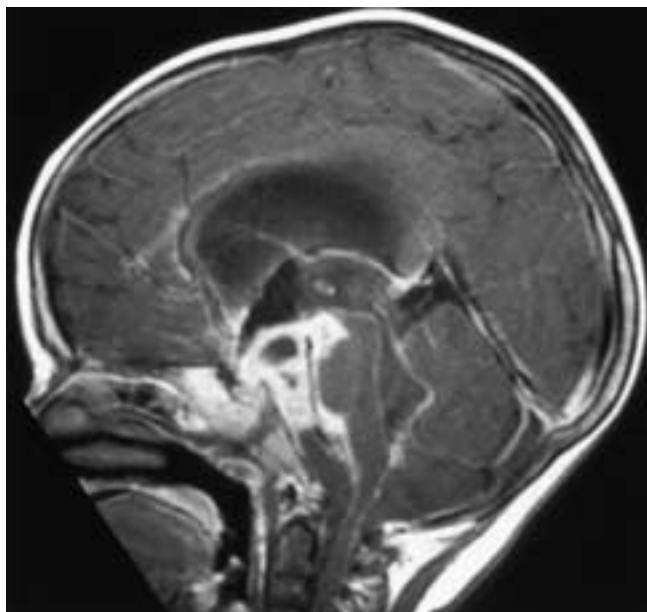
Tuberculous meningitis. Infant with hydrocephalus and cranial nerve palsies. Sagittal T1-weighted image after gadolinium injection shows a contrast-enhancing suprasellar subarachnoid collection encasing the chiasm and anterior brainstem. Findings are consistent with granulomatous meningitis at the base of the brain.
